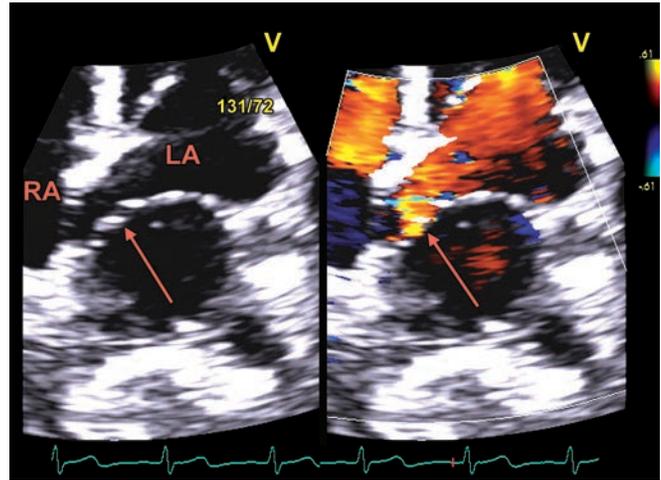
Apical 4-chamber view of the membrane in the left atrium with color flow Doppler demonstrating flow across the membrane with some turbulence (arrow).
